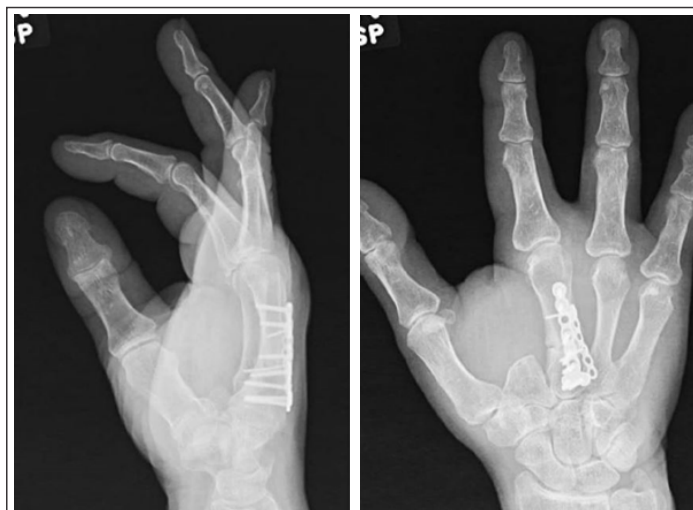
Four-month follow-up X-rays.
